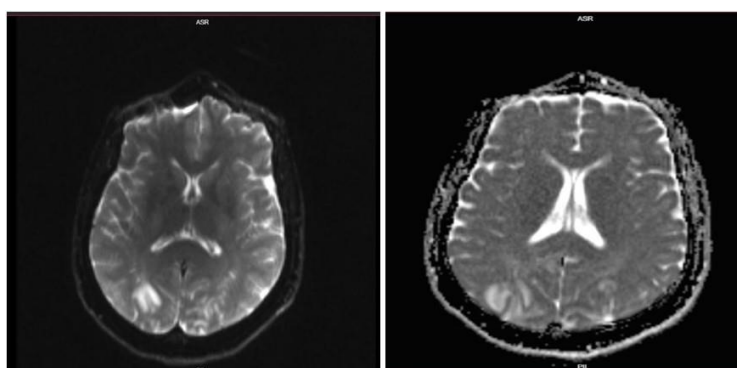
MRI image showing cortical/subcortical lesions in the occipital lobes.
